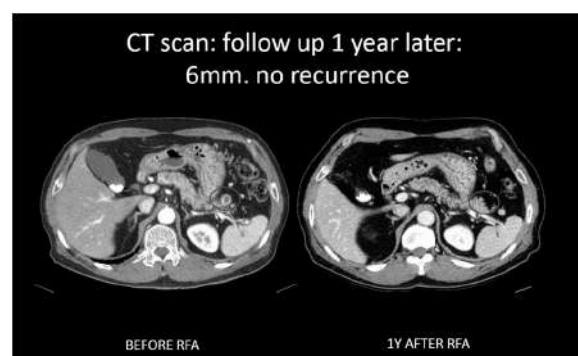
Figure before and after radiofrequency ablation (RFA). CT, computed tomography.
